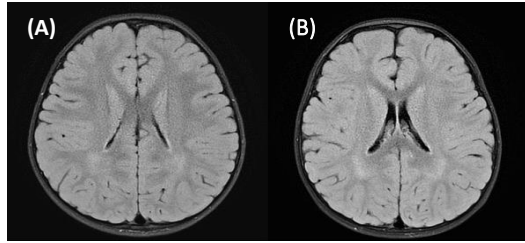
(A) Brain MRI of sibling A. (B) Brain MRI of sibling B.
